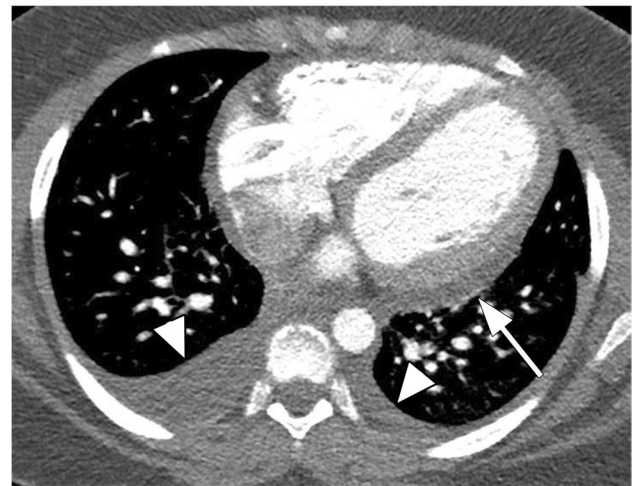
Chest CT findings in a 10-year-old girl with multisystem inflammatory syndrome in children (MIS-C) who presented with fever and chest and abdominal pain. Axial contrast-enhanced chest CT image in soft-tissue window demonstrates cardiomegaly, small pericardial effusion (*arrow*) and bilateral small pleural effusions (*arrowheads*)
